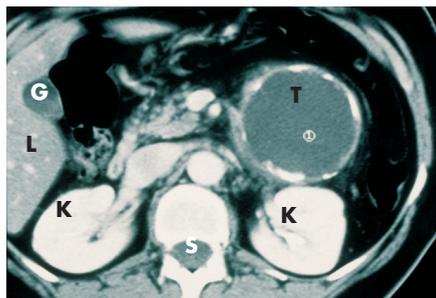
A CT image of a mucinous cystic neoplasm in the pancreas. The thick wall shows focal calcification. T = tumour, K = kidney, L = liver, S = spinal cord, G = gallbladder
